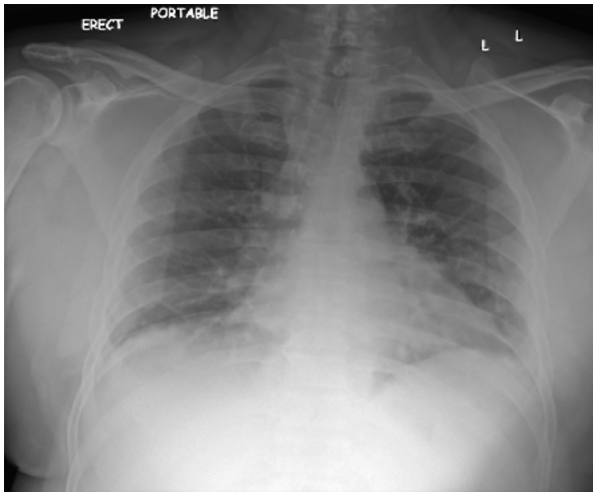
Chest X-ray at admission revealing multifocal bilateral pulmonary patchy opacities consistent with multifocal pneumonia. No pneumomediastinum or pneumothorax was noted.
